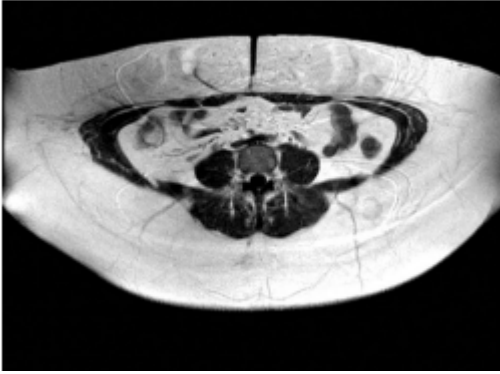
Abdominal MR image from a volunteer too large to be fully imaged with a maximum available field-of-view of a standard 1.5T clinical scanner.
